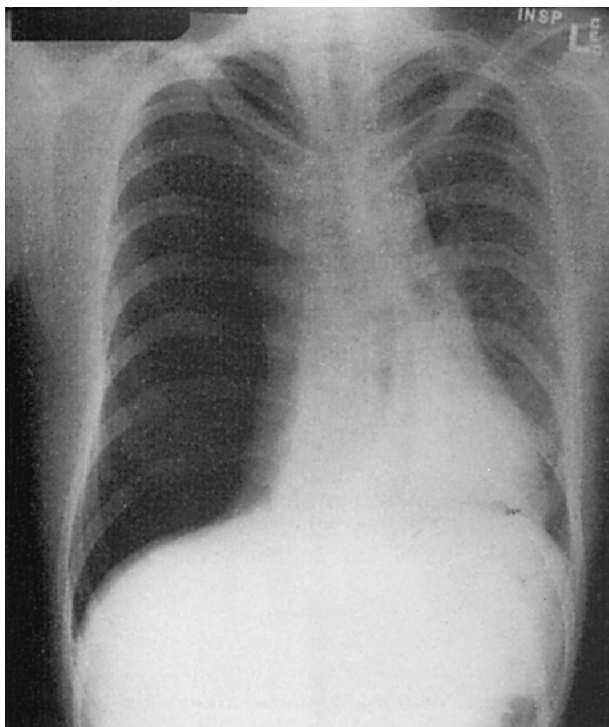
Radiograph of tension pneumothorax. The right hemithorax is dark (lucent) because the mediastinum has shifted to the left. (From Marx JA, Hockberger RS, Walls RM, eds. *Rosen's emergency medicine: concepts and clinical practice*. 7th ed. Philadelphia: Mosby, 2009, Fig. 75-3.)
